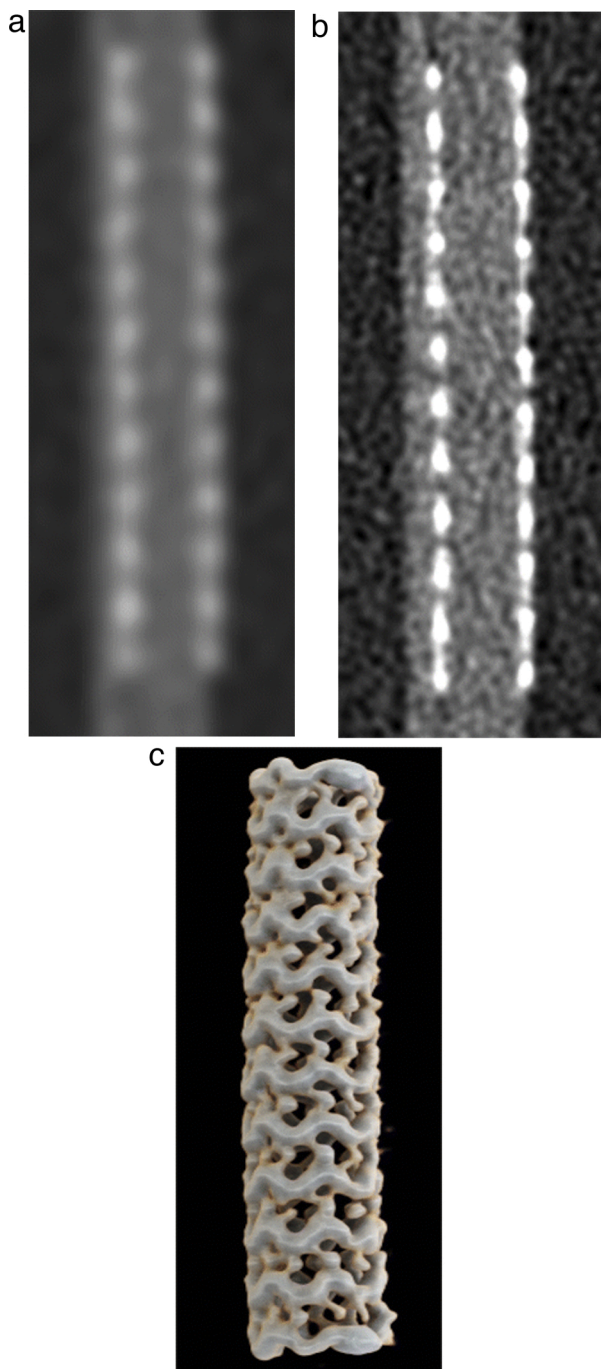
Superior image quality with Photon-counting detector (PCD) CT. Coronal conventional CT (a) and PCD CT image (b) acquired in ultra-high resolution mode demonstrate better spatial resolution and delineation of coronary stent struts on PCD CT image, enabling reconstruction of a detailed three-dimensional volume rendered image(c).
